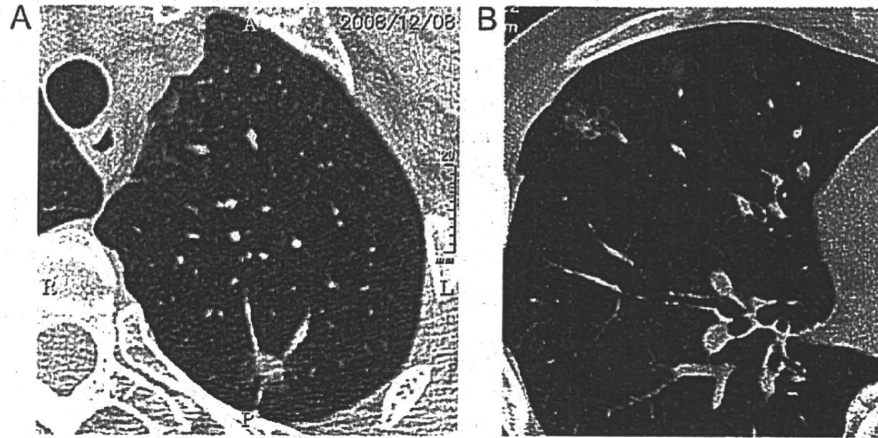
High-resolution CT image of a mixed nodule. (A) Adenocarcinoma and (B) adenocarcinoma.
